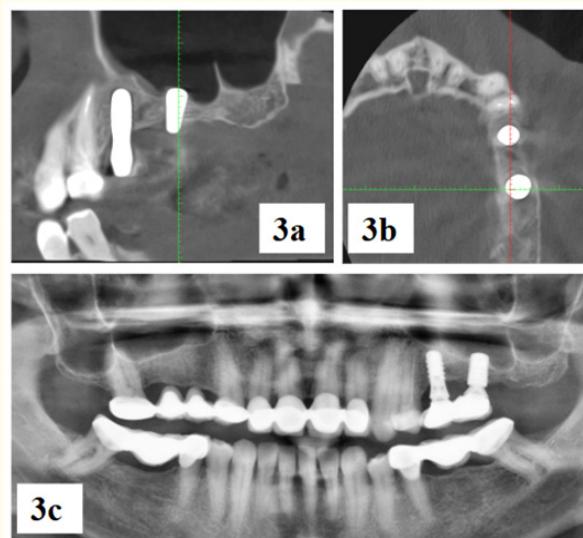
3a. 1-year follow-up CBCT sagittal view, confirming implant osseointegration and stable bone regeneration following ridge splitting and sinus lifting. 3b. CBCT axial view, showing the positioning of the implants within the bone augmented in the ridge after 1 year. 3c. A 2 year-follow-up panoramic x-ray demonstrating a precise placement of the implant with the prostheses.
